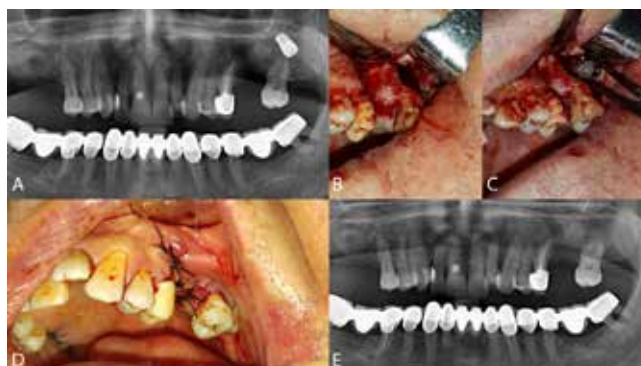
A. Preoperative radiograph. B. Intraoperative view of implant removal through an intraoral approach after having raised a mucoperiosteal flap a small portion of the anterior aspect of the maxillary wall is removed to allow access to the sinus. C. The implant is removed through the intraoral access. D. Suture of the surgical access. E. Postoperative panoramic radiograph.
